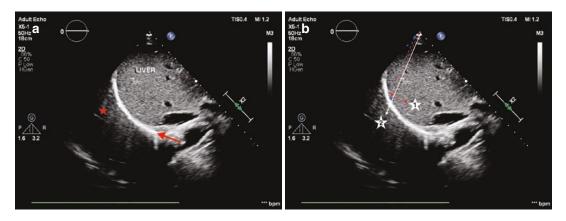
Abdominal ultrasound – coronal image of the liver. (a) A mirror image of the liver (*red star*) cephalad to the diaphragm (*red arrow*). (b) Ultrasound waves emitted from the probe (*red dashed arrow*) reflect off a structure (*white star "1"*) after being deflected by the diaphragm.
